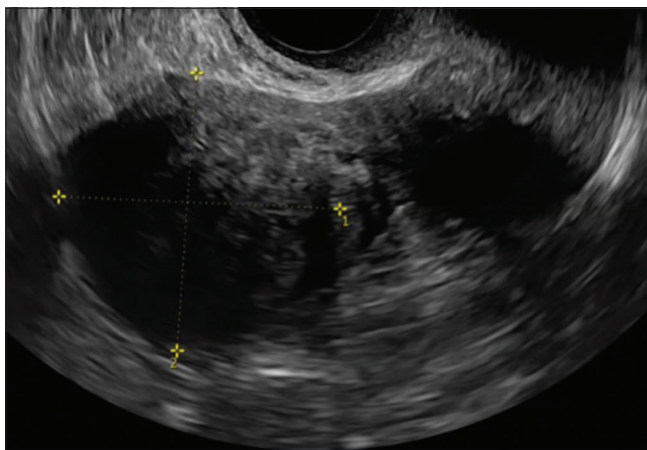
Transvaginal ultrasound in transverse view, showing a heterogeneous mass at the right posterolateral portion of the uterus described as a subserous myoma
